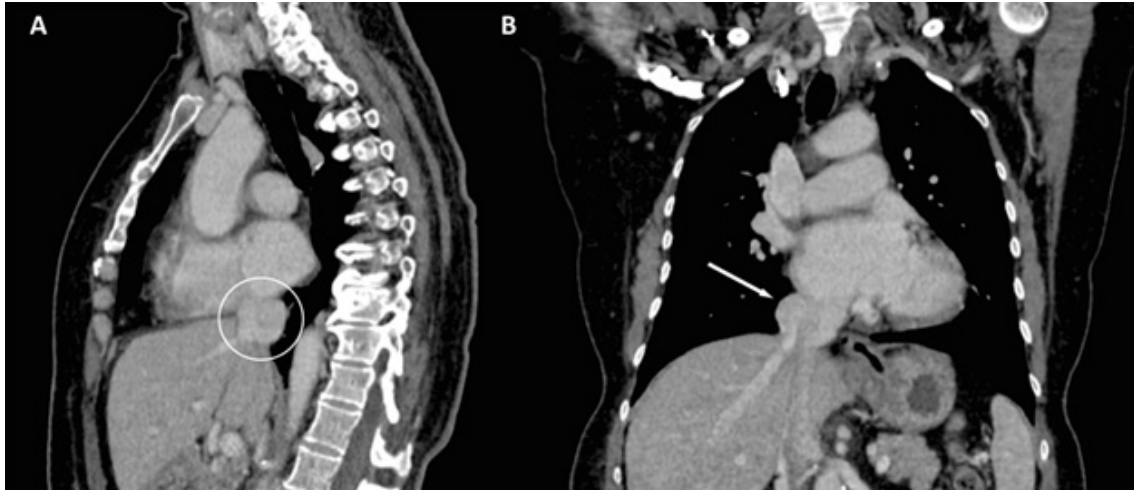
Chest CT. A) Chest CT with IV contrast administration, sagittal section, showing an IVC aneurysm (white circle); B) Chest CT with IV contrast administration, coronal section, demonstrating a suprahepatic IVC aneurysm adjacent to the right atrium (white arrow). CT: computed tomography; IVC: inferior vena cava.
